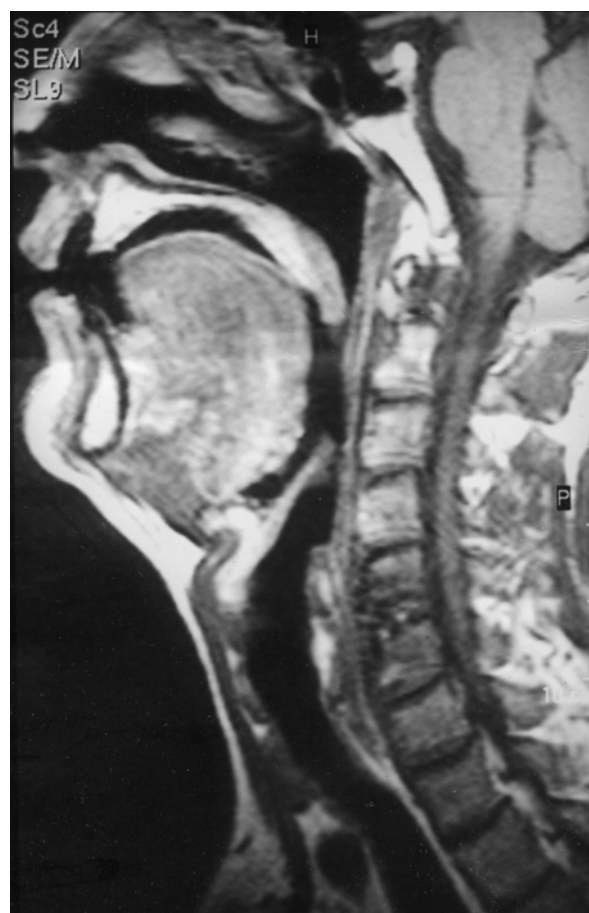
MRI of the head and neck showing that the uvula contacted the posterior nasopharyngeal wall during the expiratory phase of breathing.
